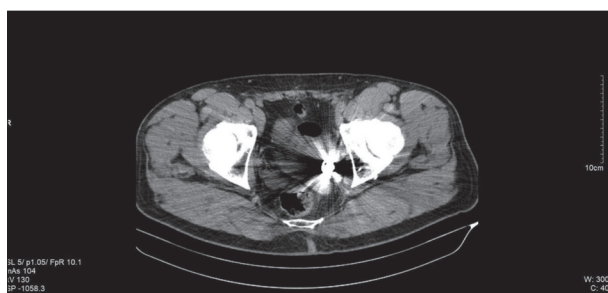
Computed tomography of the pelvis showing a foreign body with metallic density in the bladder cavity
